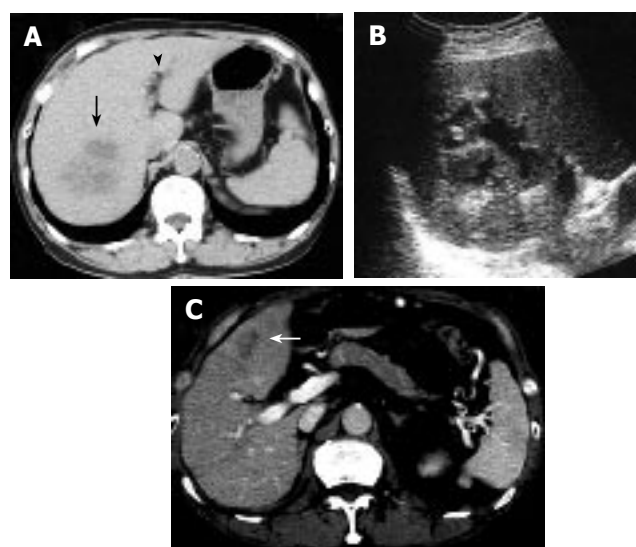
Computed tomography scan showing an abscess in the right anteroinferior segment of the liver (black arrow). Pneumobilia is detected (black arrowhead) (A). Ultrasonography shows partial liquefaction in the abscess (B). Computed tomography scan showing an abscess in the left medial segment of the liver (white arrow) (C). Note that the pancreas is not swollen.
